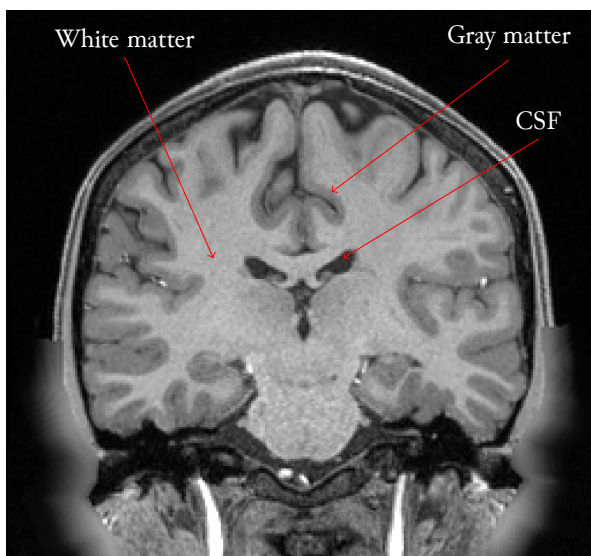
A structural T1w image showing the white matter (in white), the gray matter (in gray) and the CSF (in black). It is not possible to distinguish the organization of the underlying white matter on a T1w image, but this is possible using diffusion MRI. The figure is adapted from St-Jean (2015).
